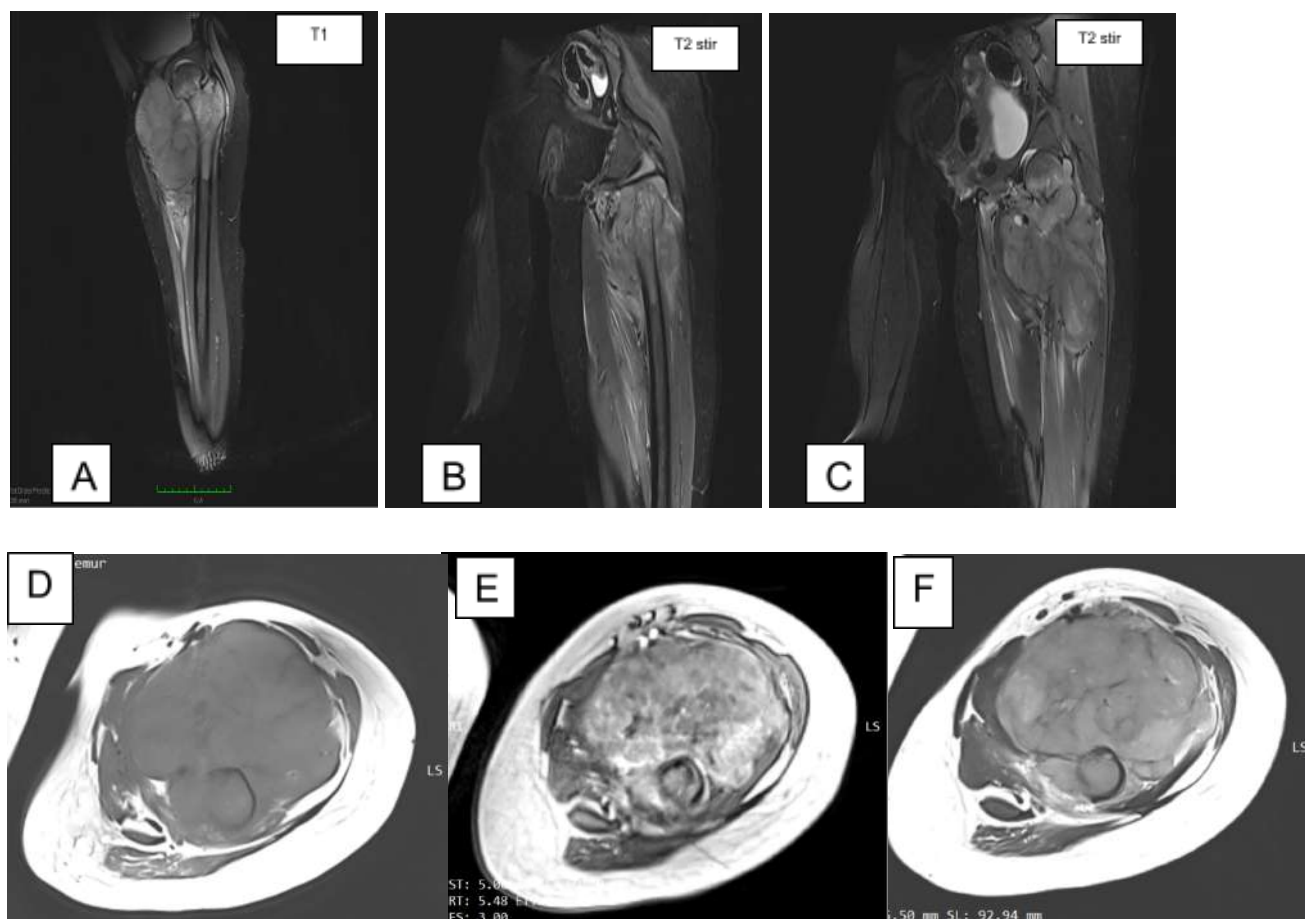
MRI of the left femur demonstrating an aggressive bone tumor with extensive soft tissue involvement, (A) T1 sagittal, (B,C) Coronal Short-Tau Inversion Recovery (STIR) T2. (D) T1 Axial, (E) T1 Axial + Contrast, (F) T2 Axial
